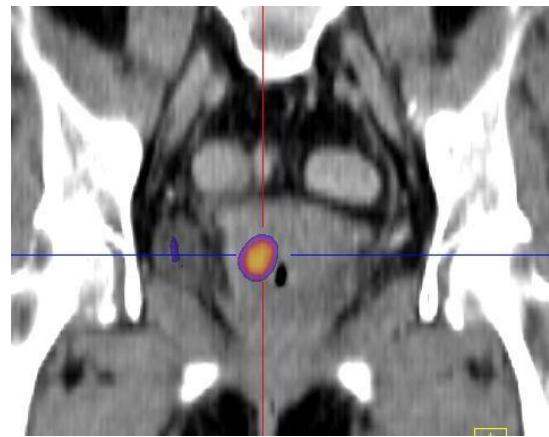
Coronal fused PET/CT image shows the location of the FDG-avid melanoma in the upper 1/3 of the right vaginal fornix.
